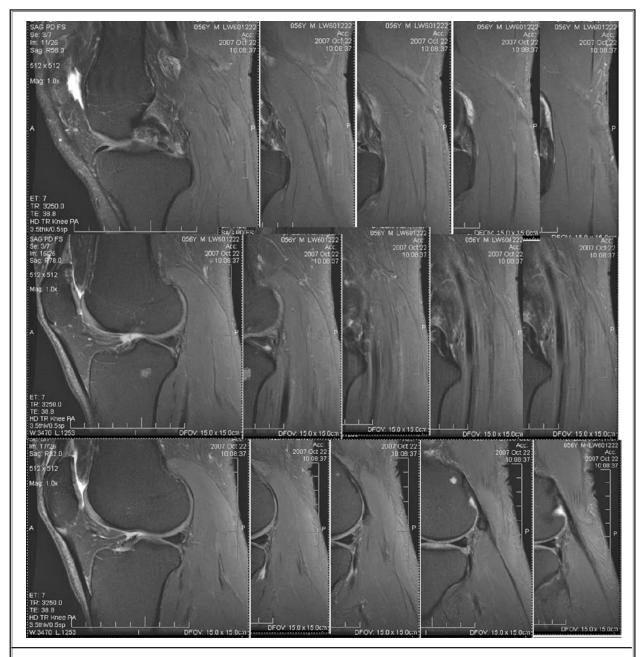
MRI sagittal slices showing where cyst once resided.
